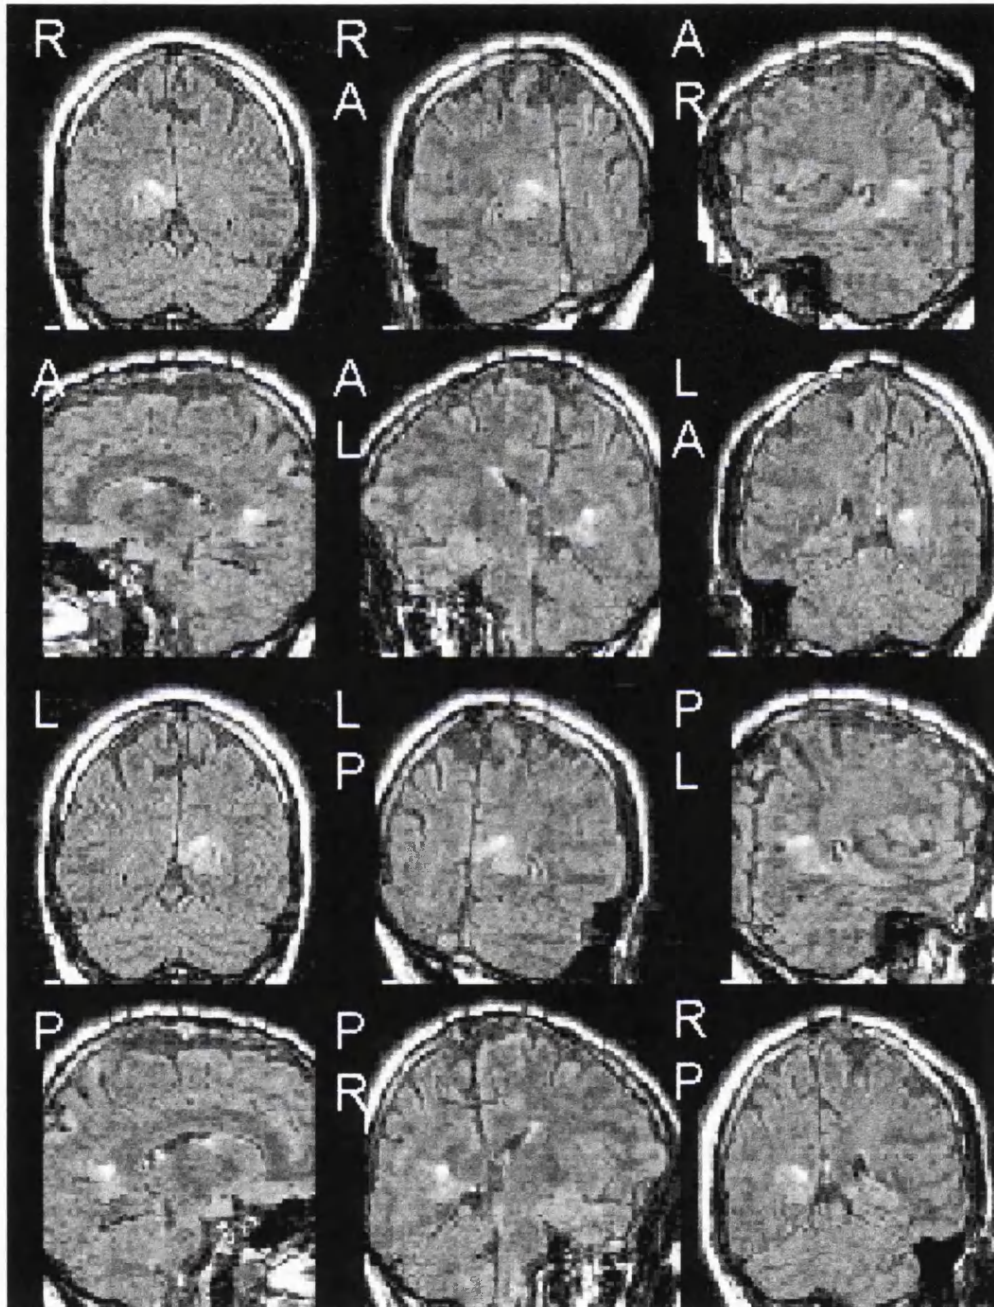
REFORMATTED 3D fast FLAIR of the same patient. A lesion is clearly visible in the cortex above the anterior extremity of the right calcarine sulcus involving the isthmial gyrus. Note also Venetian blind artefacts at slab interfaces (best visible on reformatted images in the sagittal plane, which is orthogonal to the imaging plane).
